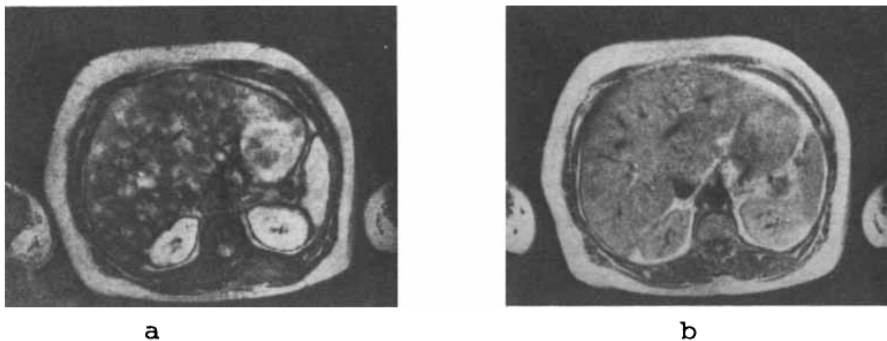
MR images made with a spin-echo pulse sequence (40 ms echo time, 1.5 s repetition time, 4 averages, 0.35 T) where a) shows the result of imaging with a conventional spin-echo pulse sequence and b) shows the result obtained with the modified spin-echo pulse sequence shown above.
